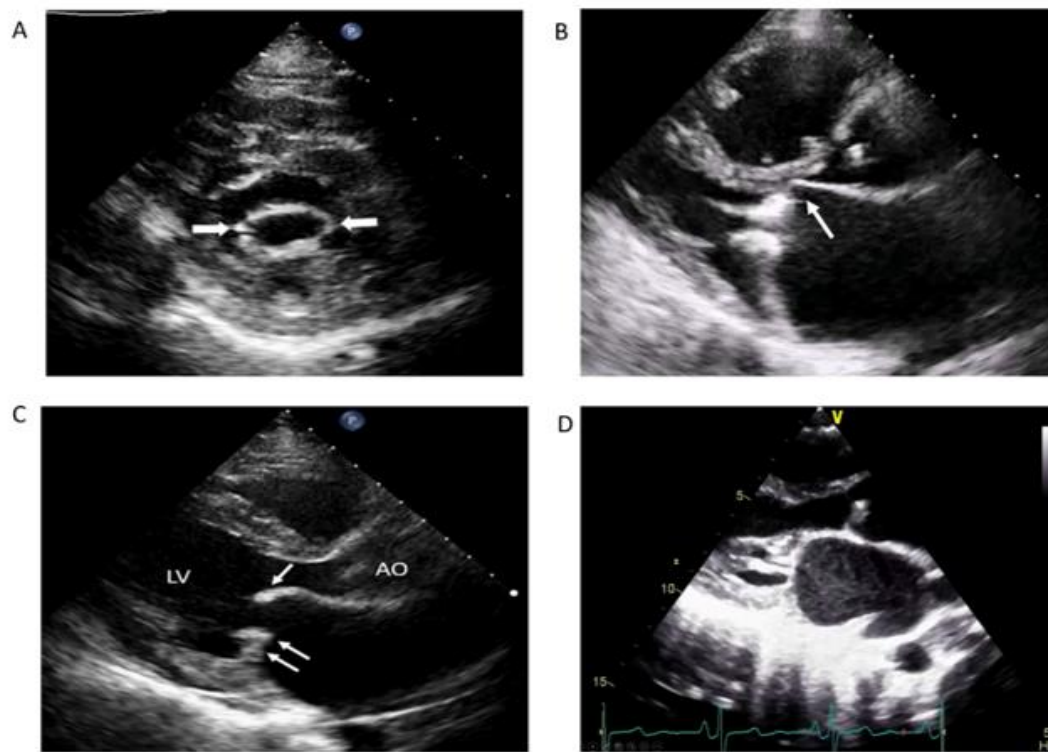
2D echocardiography findings of MS. (A) Bi-commissural fusion (arrows) of a rheumatic valve in parasternal short-axis view. (B) Thickened and calcified mitral valve leaflets seen in parasternal long-axis view, with diastolic doming of the anterior leaflet (arrow). (C) Thickened and doming mitral anterior leaflet (single white arrow) and restricted motion of posterior leaflet (double arrows) in parasternal long-axis view. (D) Chordal thickening and calcification seen in parasternal long-axis view.
